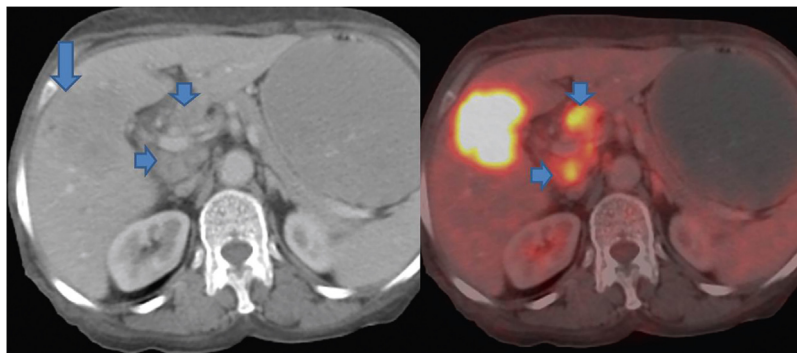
PET-CT shows an ill-defined hypodense mass replacing the GB fossa (arrow) showing marked FDG avidity. In addition, multiple FDG avid periportal lymph nodes are seen (short arrows).
